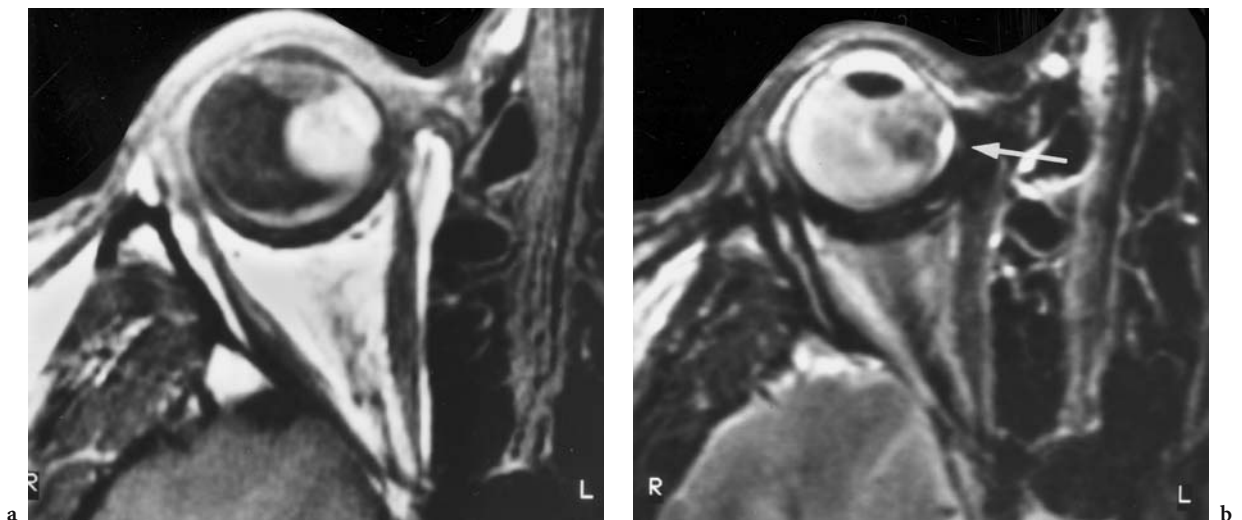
A 46-year-old woman with visual loss of the left eye. Diagnosis: choroidal melanoma, extending to the ciliary body of the left globe. MRI: a Axial T1-weighted, contrast-enhanced image showing a well-defined, homogeneous lesion at the medial circumference of the right globe, extending to the medial ciliary body, and along the posterior choroid. b Corresponding T2-weighted image allowing visualization of the hypointense signal of the melanin (caused by its susceptibility). Note the faint fluid signal corresponding to a slight, associated retinal detachment (*white arrow*) and imposing as a small, hypointense area on the T1-weighted image (a)
